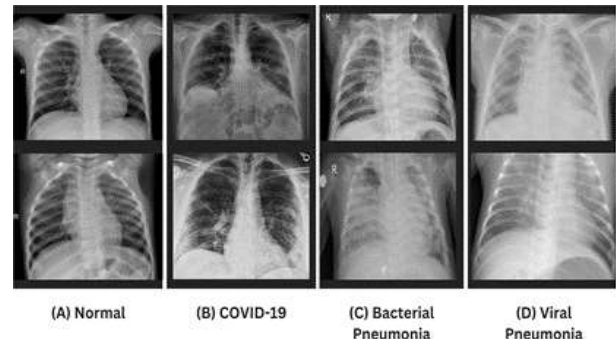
Images of posterior-anterior chest X-rays from COVID-19: A Curated Dataset (X-Rays), [11]
